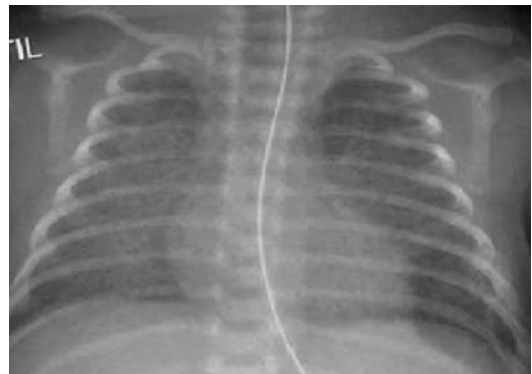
New bronchopulmonary dysplasia. Anteroposterior chest X-ray shows subtle and diffuse interstitial images in a 60-day-old child, who was a 27-week premature newborn, with birth weight 1280 g, and received surfactant treatment
